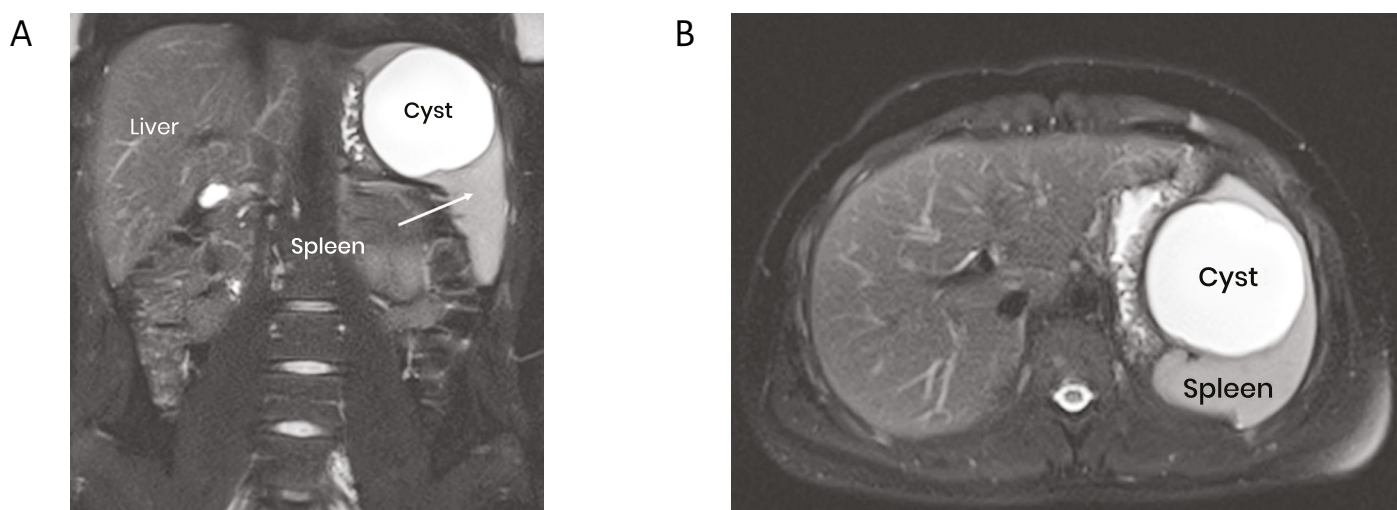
(A) Case no. 2. Abdominal CT with view of giant splenic cyst (p-a view); (B) Case no. 2. Abdominal CT with view of giant splenic cyst (horizontal view).
